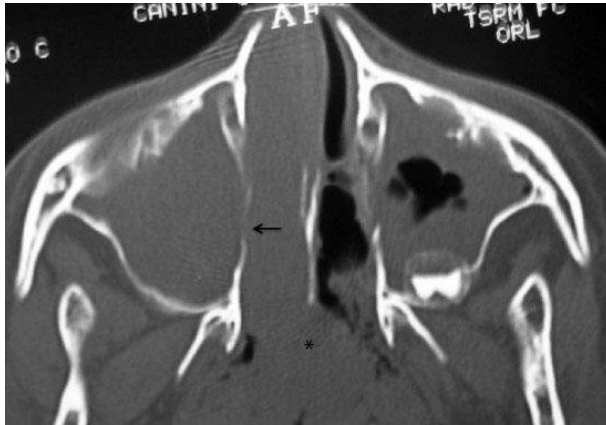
At CT scan, Antrochoanal polyp fills the right maxillary sinus growing the natural ostium (arrow) into the middle meatus to the choana (asterisk).
